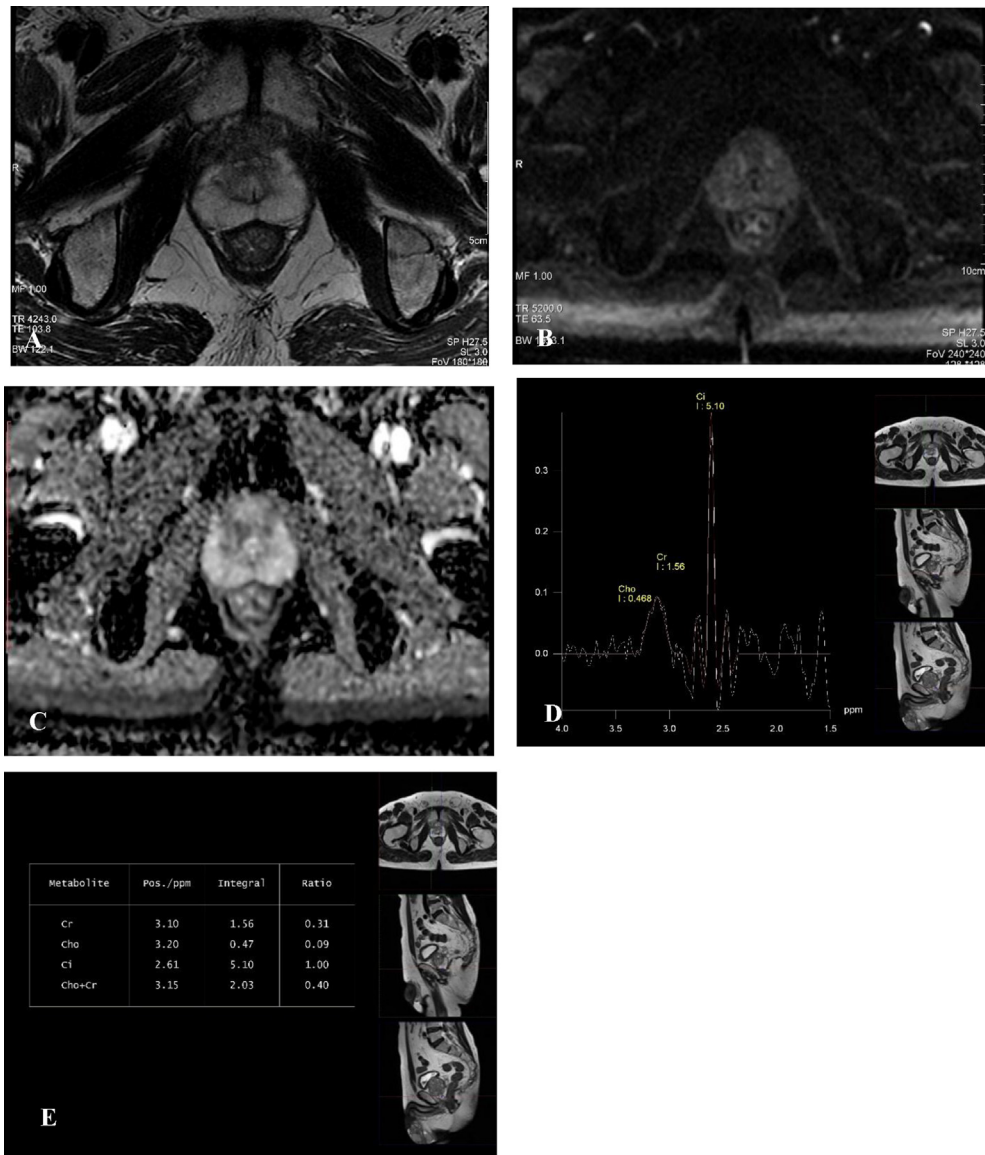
Multiparametric MR images of a normal prostate. The peripheral zone shows the high signal intensity on the T2WI and ADC map. The MRS images shows prominent citrate peak at a frequency of 2.6 ppm and choline peak at 3.2 ppm. (A) Axial T2WI, (B) Axial DWI, (C) Axial ADC, (D) MRS, (E) MRS biochemical parameter. Cr. = Creatinine, Cho. = Choline, Ci. = Citrate.
